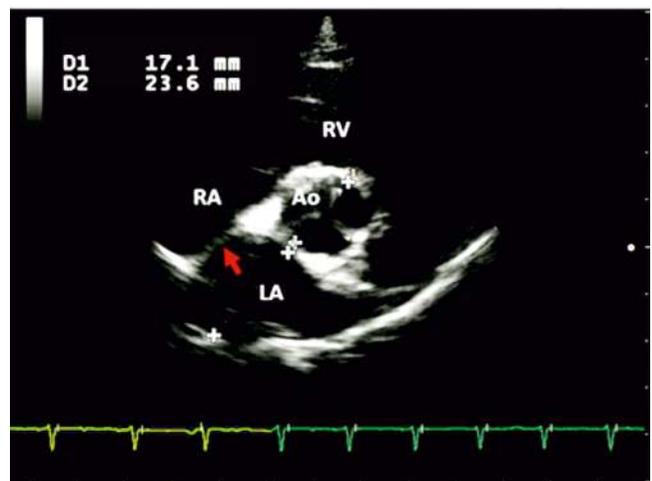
Parasternal short axis view at the heart base and aorta level (RV-right ventricle, RA-right atrium, LA-left atrium, Ao-aorta, the red arrow-interatrial septum)
